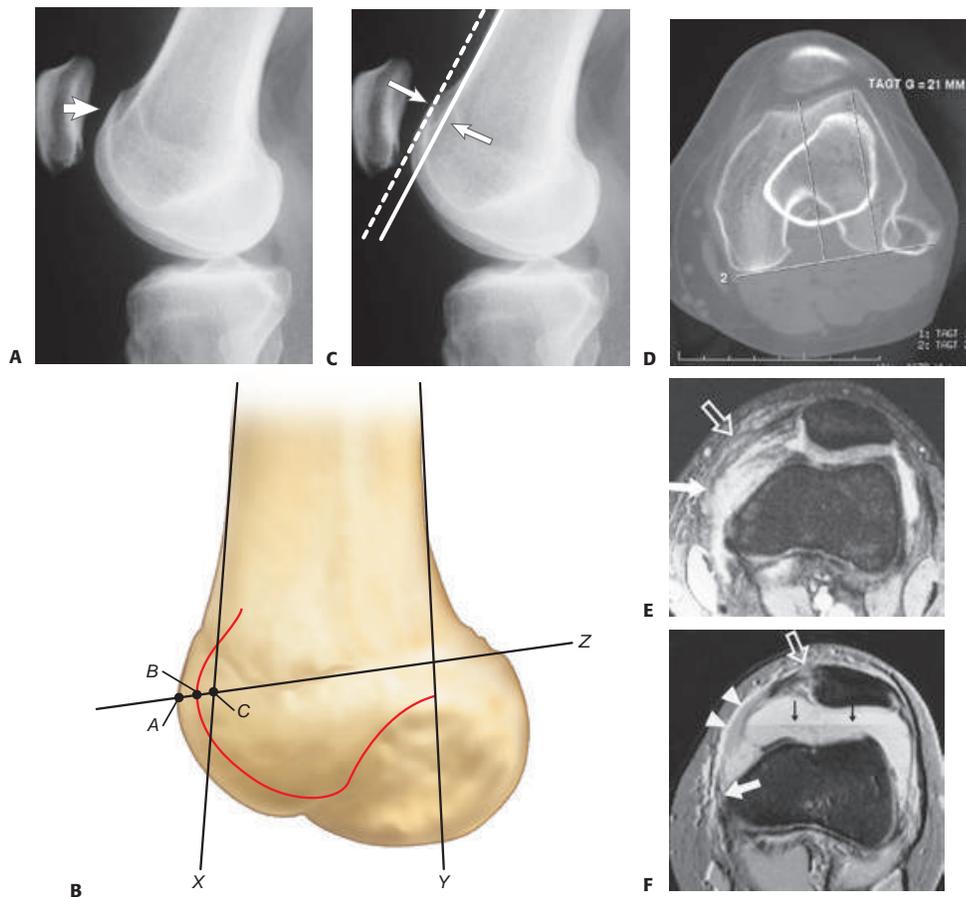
• A. On a true lateral radiograph, trochlear dysplasia is evident when the floor of the trochlea crosses the anterior borders of both femoral condyles (ie, the “crossing” sign). B. Measurement of the trochlear prominence on the lateral view according to Dejour et al⁶. X and Y are lines tangential to the anterior and posterior cortices of the distal femoral metaphysis, respectively. Line Z crosses the most prominent point of the line of the trochlear groove (point B) and the upper aspect of the posterior border of the condyles. Line Z crosses the anterior aspect of the lateral condyle (point A) and line X (point C). The distance BC (in mm) is the trochlear prominence. C. Lateral radiograph demonstrating a knee with positive trochlear prominence. Note that the floor of the trochlea lies anterior to the line tangential to the anterior cortex of the distal femur. D. Measurement of the tibial tuberosity–trochlear groove (TT–TG) offset, the transverse distance between the apex of the anterior tibial tuberosity and the center of the trochlear groove. Measurements are made on superimposed axial CT or MRI images. E,F. MPFL injury appearance on MRI. E. Transverse gradient echo image of the knee obtained at the level of the insertion of the adductor magnus tendon 3 weeks after lateral patellar dislocation demonstrates a complete tear of the femoral origin of the MPFL, with MPFL fibers retracted anteriorly (*solid arrow*). Partial injury, with surrounding edema, to the midsubstance of the patellar retinaculum (*open arrow*) also is seen. F. Transverse gradient echo image of the knee in a different patient 2 days after lateral patellar dislocation showing partial injury to the femoral origin of the MPFL. The MPFL fibers (*solid white arrow*) are wavy and show longitudinal split, and there is extensive surrounding edema. A complete tear (*open arrow*) is seen in the patellar insertion of the medial patellar retinaculum. A large joint effusion with layering (*black arrows*) is present, consistent with hemarthrosis. Note also the inferior fibers of the VMO (*arrowheads*).
